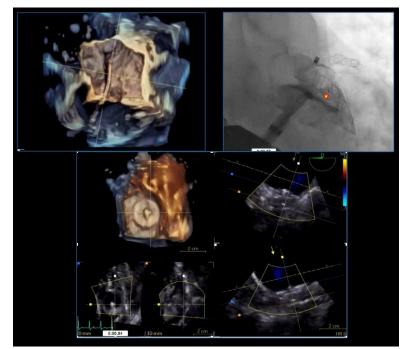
CTA facilitating planning of a "mid-mid" transseptal puncture, rather than inferoposterior as previously described, and the successful deployment and LAA exclusion.
